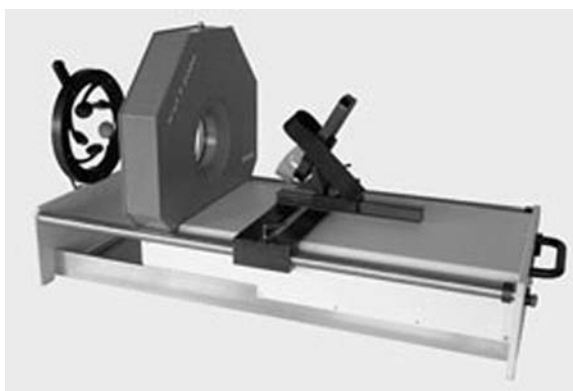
The Stratec XCT 2000LTM. A peripheral quantitative computed tomography device. Photograph courtesy of Orthometrix, Inc., White Plains, NY.
